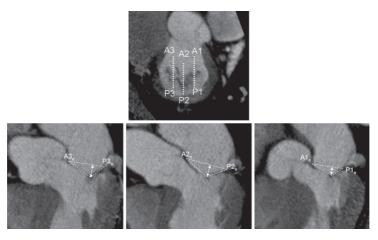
Mitral valve geometry assessment with multidetector row computed tomography (*MDCT*) in functional mitral regurgitation. From the short-axis view of the mitral valve at the level of the mitral leaflets and commissures, the orthogonal
